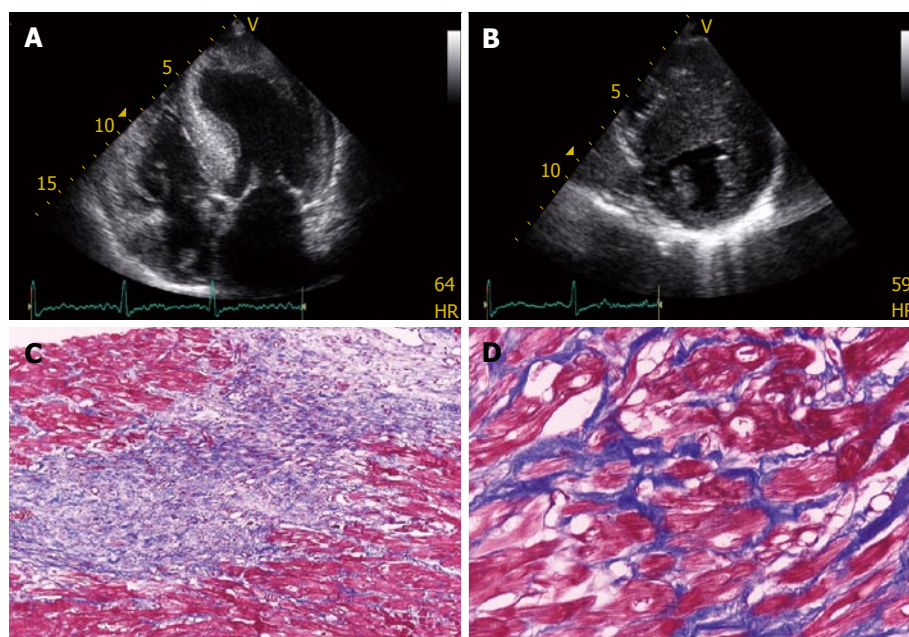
Echocardiographical and pathological features of hypertrophic cardiomyopathy. A: An apical 4-chamber view of a patient with hypertrophic cardiomyopathy showing a hypertrophied, non-dilated left ventricle; B: Excessive thickness of interventricular septum (eccentric hypertrophy) is also optimally visualized from parasternal short axis views; C: Myocardial disarray and extensive fibrosis ($\times 10$ Trichrome Masson); D: Myocardial disarray and interstitial fibrosis ($\times 40$ Trichrome Masson).
